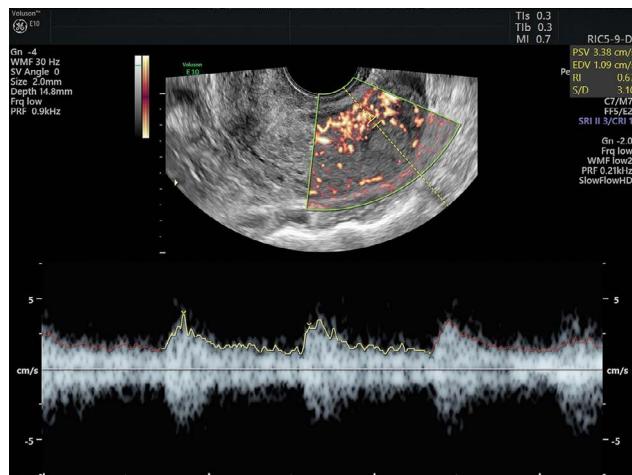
Slowflow Doppler of the endometrium.
